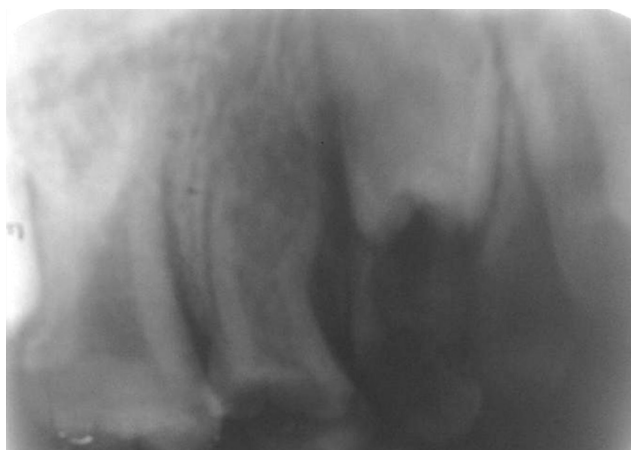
Intraoral Periapical radiograph of upper left posterior teeth
